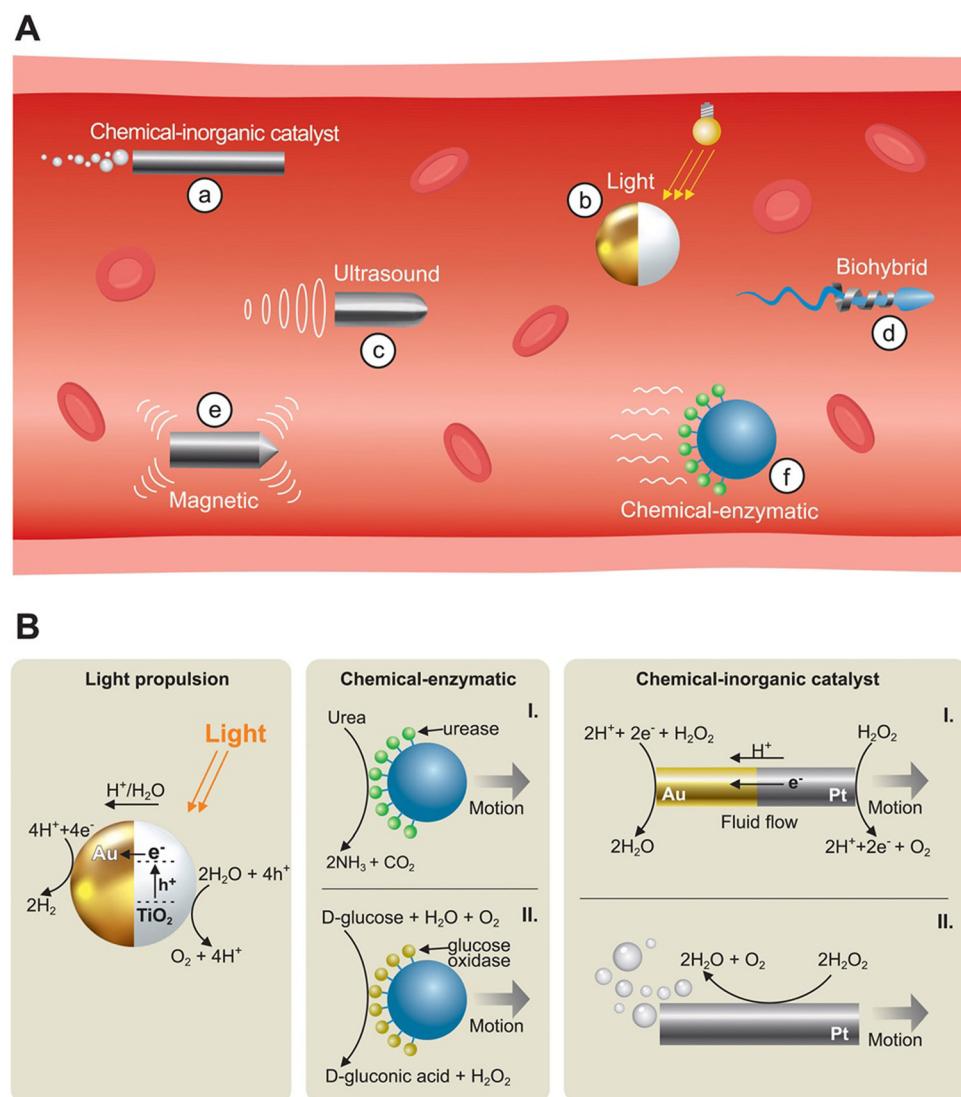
Types of propulsion mechanisms of nanorobots. (A) Nanorobots journeying through a blood vessel. Externally powered nanorobots utilize ultrasound propulsion (c), magnetic propulsion (e), and light propulsion (b). Chemically powered nanorobots can use inorganic catalysts such as hydrogen peroxide (a) or enzymatic propulsion (f). Biohybrid nanorobots utilize cells or microorganisms together with other types of propulsion such as magnetic propulsion (d). Red elements depict red blood cells. (B) Details of selected propulsion mechanisms. From left to right: light propulsion of Au Janus-type nanorobots, enzymatic propulsion based on urease (I) and glucose oxidase (II), chemical propulsion with inorganic catalysts based on self-electrophoresis (I) and bubble propulsion (II).
